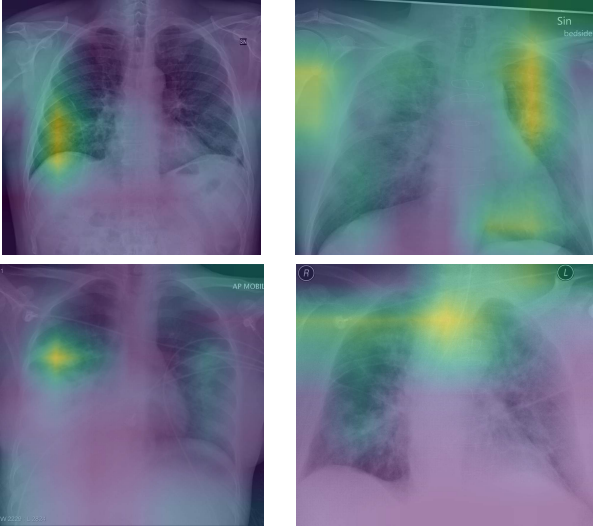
Activation map of EfficientNet B0 model. The first line are COVID-19 x-ray, and the second, other kind of pneumonia.
